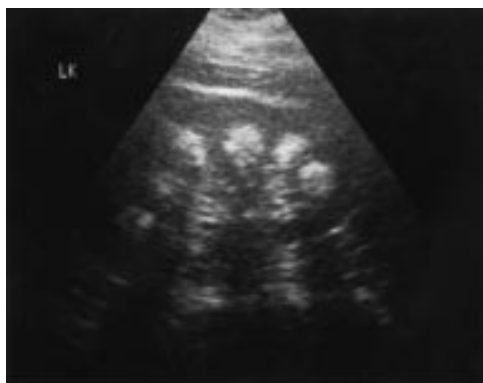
Renal ultrasound examination.
